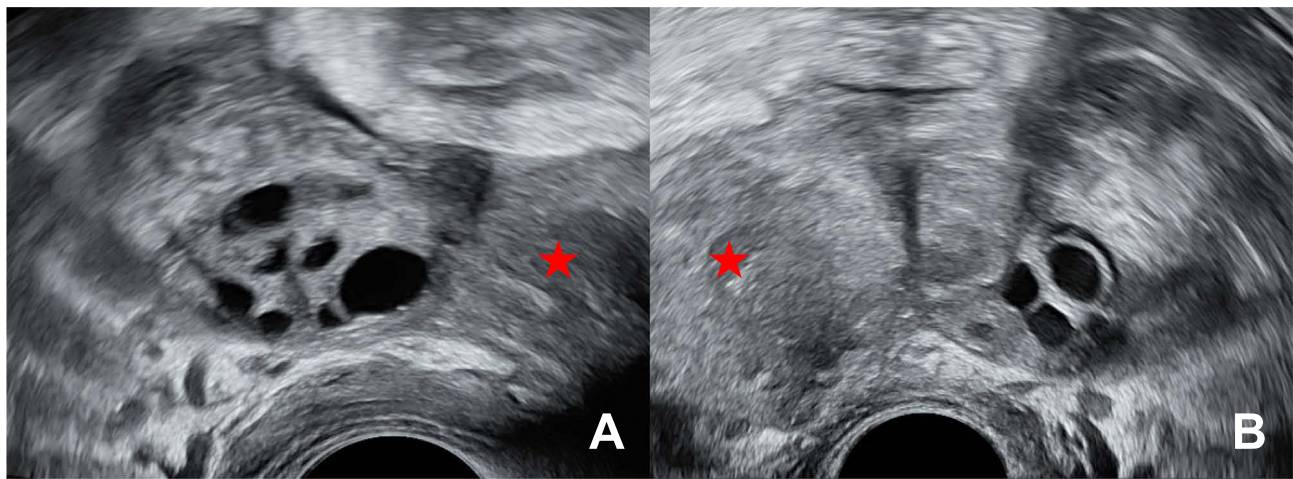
Transrectal ultrasound. (A) Right and (B) left ovary adjacent to the inhomogeneous mass in the lesser pelvis (red star).
